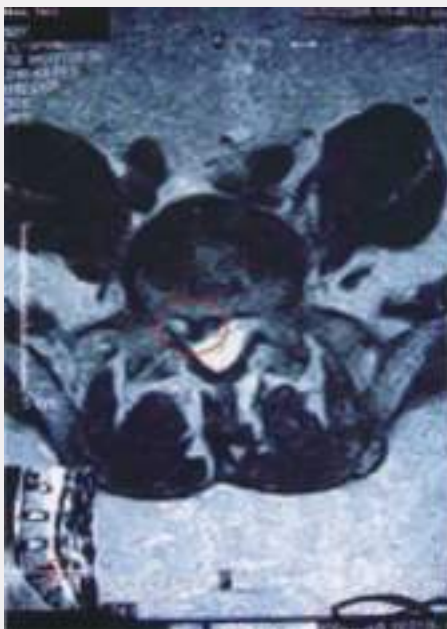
Pre-treatment MRI (02/02/05)
